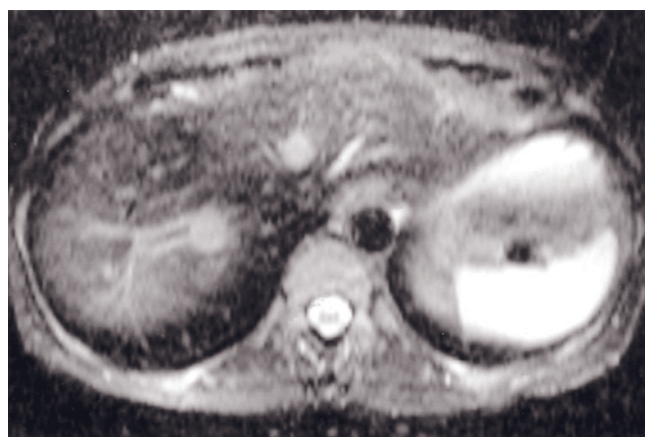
Hypervascular liver metastases. Fat-suppressed T2-weighted ETSE (a), SGE (b), and immediate (c) and 90-s (d) postgadolinium SGE images. A 7-cm metastasis is identified in the left lobe of the liver (a-d). Several metastases smaller than 1 cm
